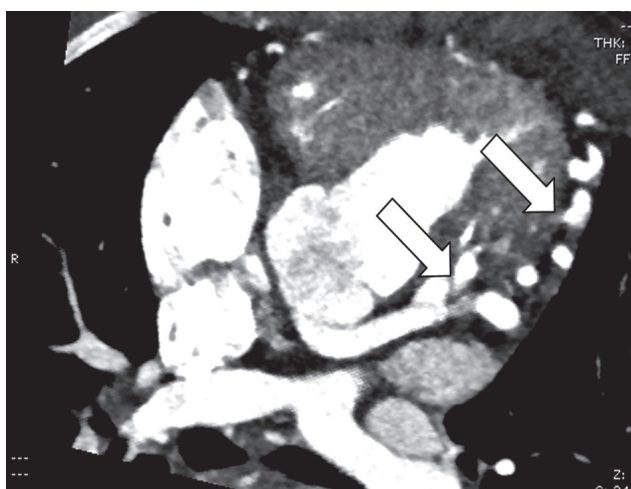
Cardiac computed tomography angiography (CCTA) of a 5-year-old girl with presumed diagnosis of pulmonary atresia with VSD. The CCTA showing new unexpected findings as single coronary artery and coronary artery fistula from left anterior descending artery to right ventricle (arrows), which changed the therapeutic management
